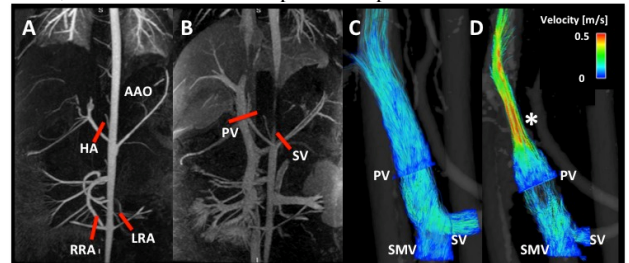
A, B: CE-MRA of the arterial and venous vasculature indicating the localization of ultrasound and MR measurements. C, D: Color-coded streamline visualization of flow before (C) and after (D) induction of portal hypertension by partial ligation of the portal vein. * indicates increased blood flow due to stenosis. For abbreviations please see Methods.
